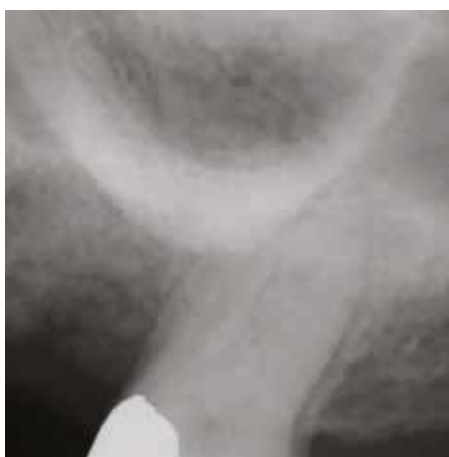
Following use of the LMHFV for 5 minutes daily for 4 months mobility has resolved and apical area has disappeared with a normal PDL space radiographically.
